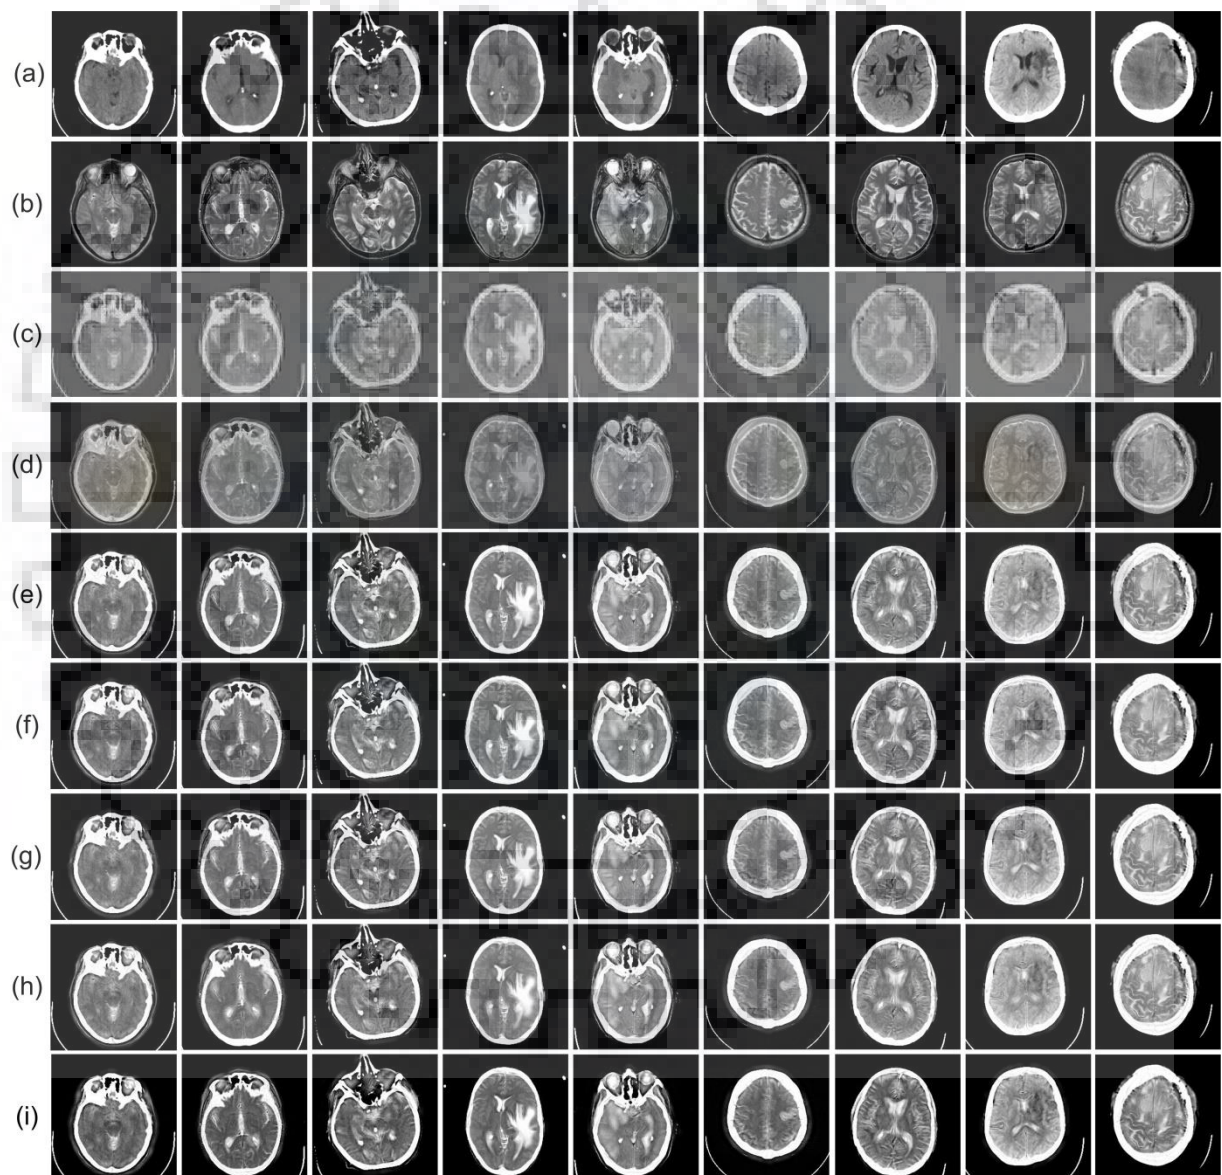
Comparative visual results obtained by the fusion methods applied to the reference (a) CT and (b) MR images. The fused image obtained by the (c) Method 1 (d) Method 2 (e) Method 3 (f) Method 4 (g) Method 5 (h) Method 6 (i) Proposed DRT-MIF method
